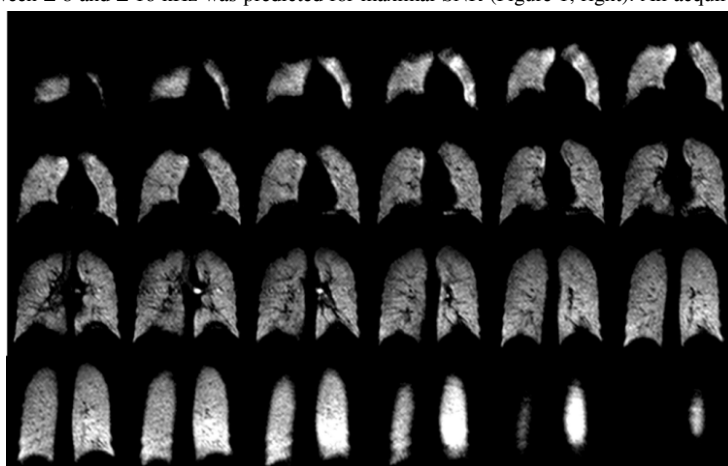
3D SSFP volumetric MRI data-set of a healthy never-smoker subject (HN1), acquired using 1 L of naturally-abundant xenon gas at 3 T.
